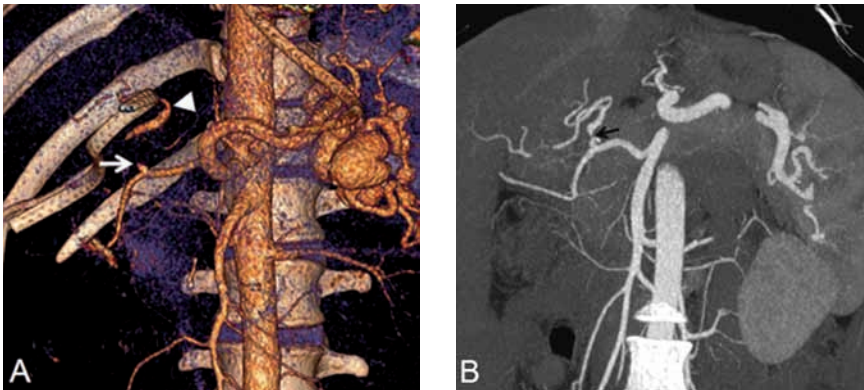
Complete absence of contrast enhancement in the hepatic artery at the hepatic hilum (arrow) consistent with short segment thrombosis in a patient with hepatic transplant (performed 2 days before imaging). VR image shows collateral filling of left hepatic artery (arrowhead) (A). Prior color Doppler US was unable to demonstrate the arterial signal at the hilum in another patient. Coronal MIP image shows the exact location of the stenosis (black arrow) (B). Catheter angiography confirmed the diagnosis.
